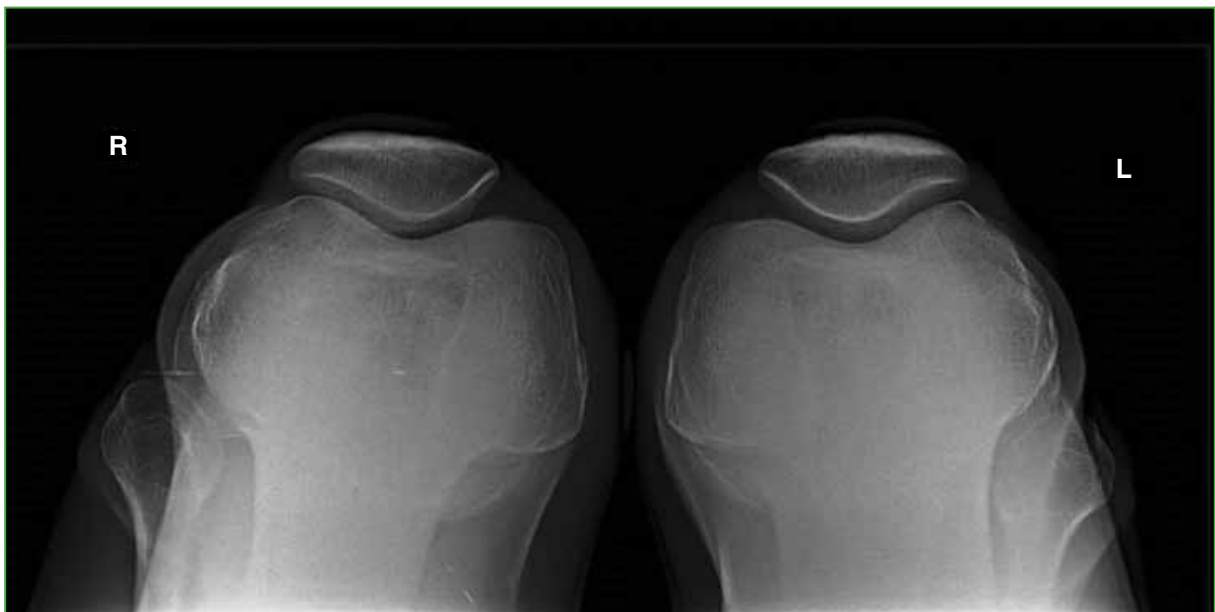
Axial patella at 30°. The axial radiograph shows a slight lateral inclination on the right knee, with decreased space between the external patellar aspect and the external femoral condyle.
